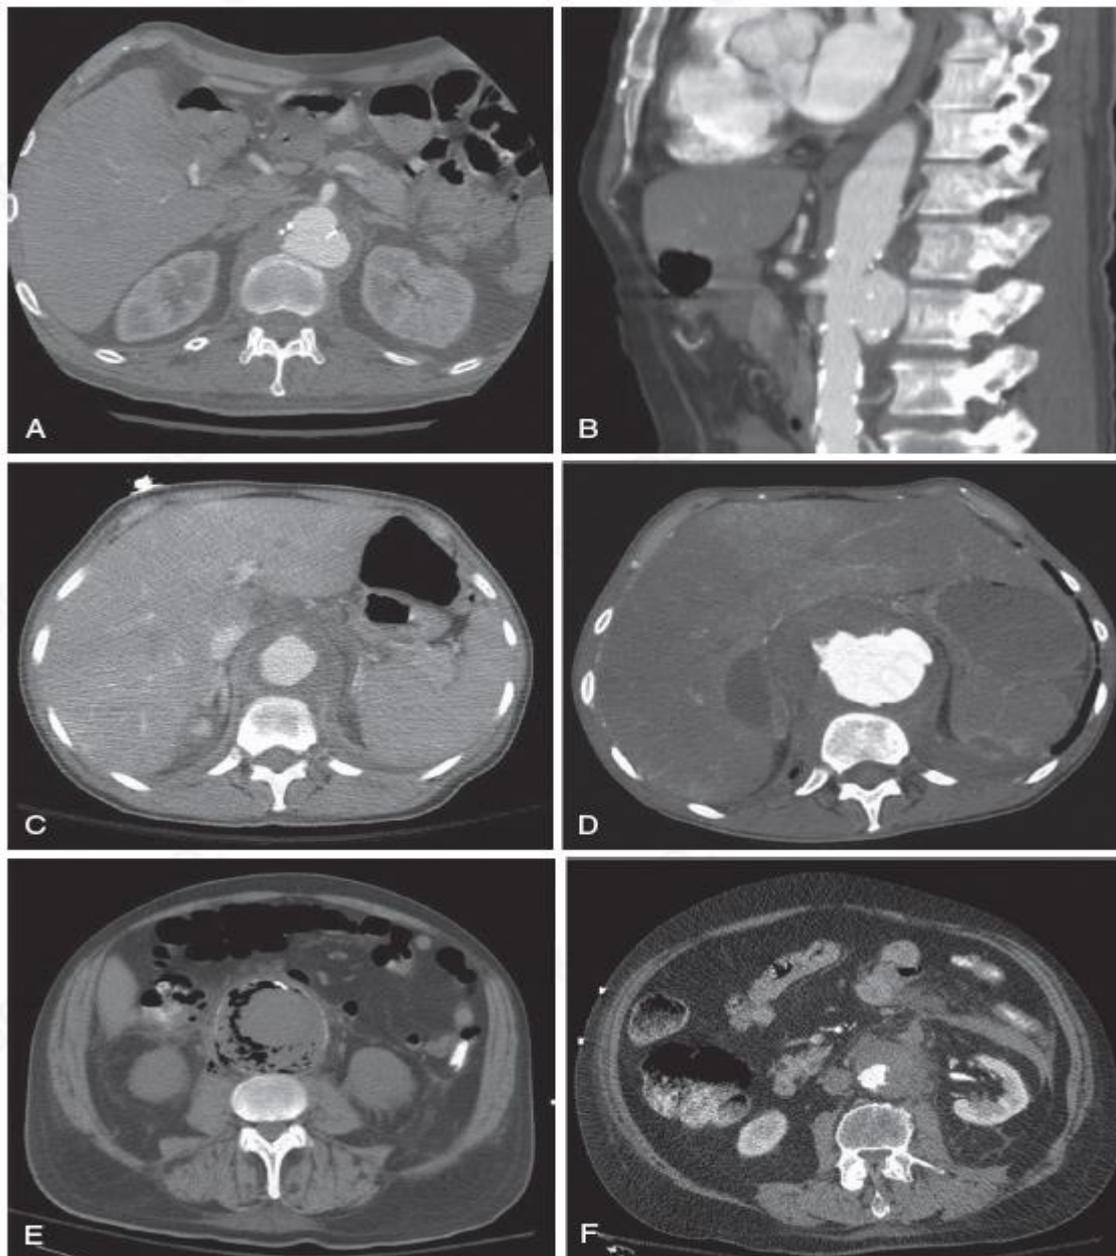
Typical features of mycotic aneurysms (MAs) on computed tomography. A, B, MAs classically present as focal outpouchings of the vascular wall, as seen on axial (A) and sagittal (B) images. In this case, there is calcification of the aortic wall, which may have been a nidus for infection. C, D, MAs tend to grow rapidly, as in this case, with images at initial presentation (C) and 2 weeks later (D). Also noted is irregularity of the aortic wall and mural thrombus. E, Inflammatory changes are common, as in this case with gas in the aortic wall in an MA due to infection by adjacent diverticulitis. F, MAs are prone to rupture. (From Deipolyi AR, Rho J, Khademhosseini A, Oklu R. Diagnosis and management of mycotic aneurysms. *Clin Imaging* 2016;40:256-62.)
